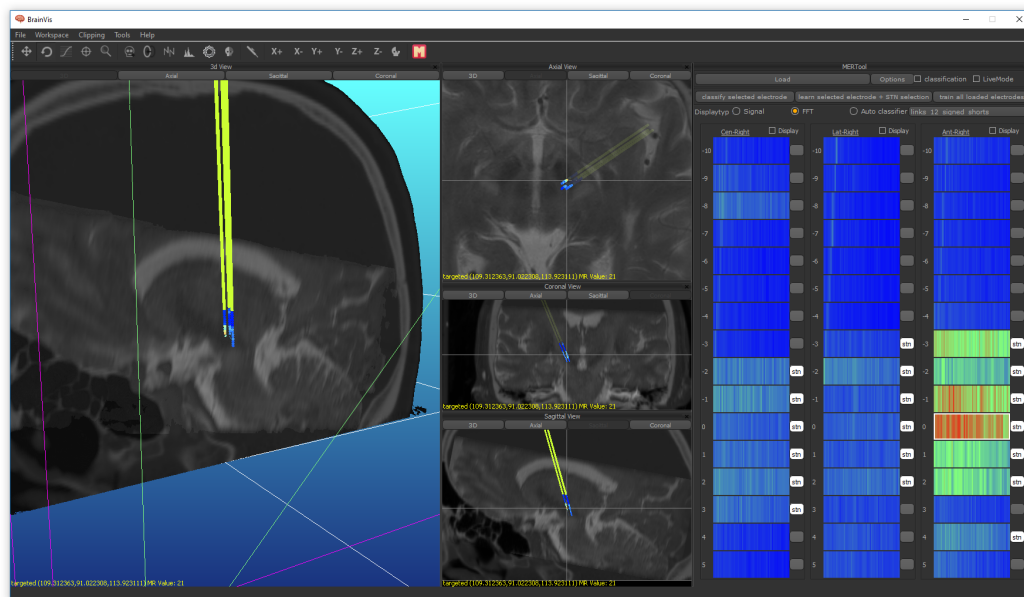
The user interface of the system is separated into two spaces. The left part of the interface displays the interactive visualization of the preoperative CT and MRI data enriched with the MER results. The right side represents the processed and analyzed MER data in real-time.
